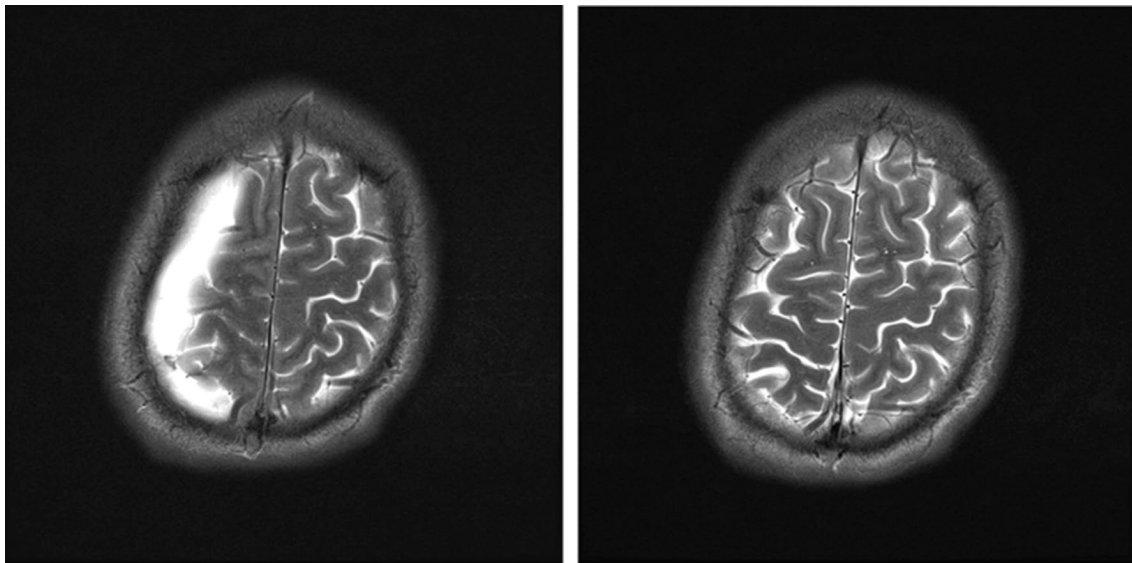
Subdural hemorrhage (left) at day 6 after surgery and spontaneous recovery (right) after 3 months in MRI (FLAIR sequences)
